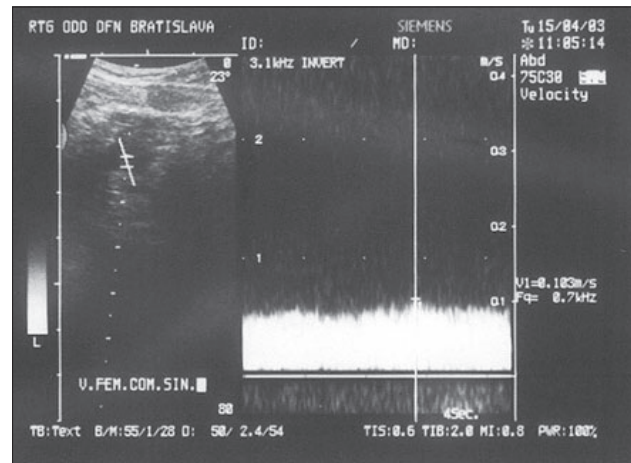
Ultrasound of venous flow.
